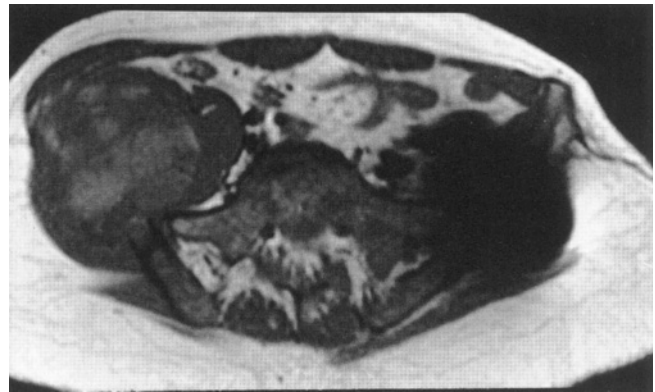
MRI scan of a high-grade sarcoma arising from the ilium, crossing the SI joint, and involving the L5 transverse process. This tumor is considered to be unresectable due to the extension along the sacrum and the lumbar spine. MRI scans are invaluable in determining extraosseous soft-tissue extension of bony tumors.
